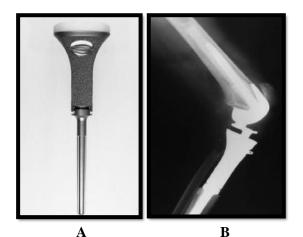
(A) The first proximal tibial component with porous coating along the entire body to permit soft-tissue attachments of the adjacent muscles as well as attachments of the patellar extensor mechanism. (B) Plain lateral radiograph of a similar prosthesis. ⁽²²⁾
